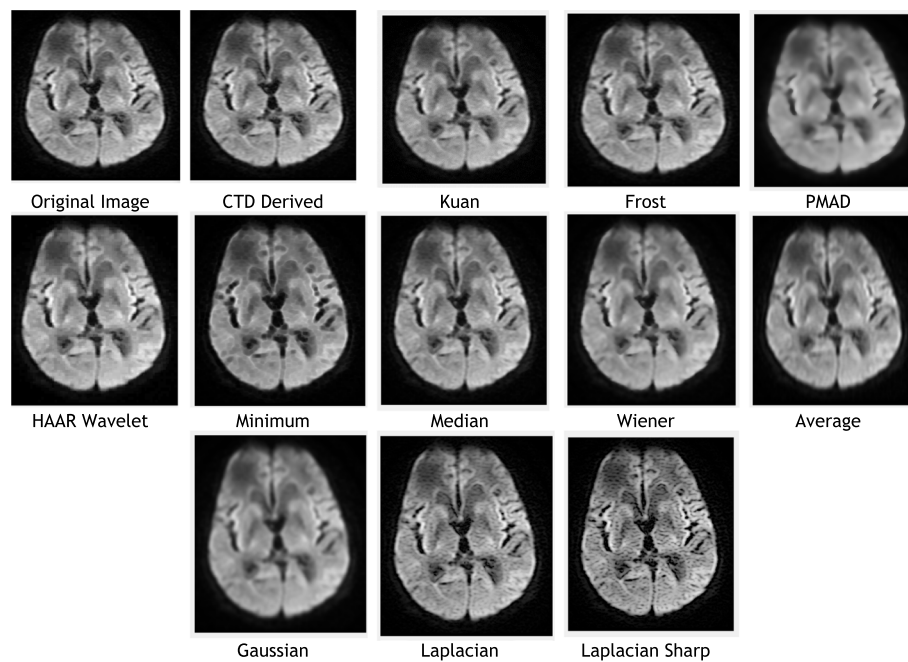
Original and denoised Images of MCA DWI (B 800) MRI
